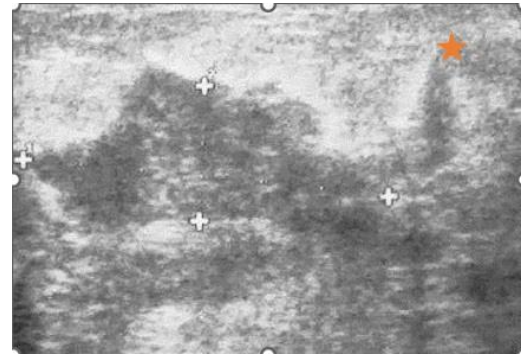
Ultrasound image showing a hypoechoic mass that has fistulized to the skin surface (Star)
